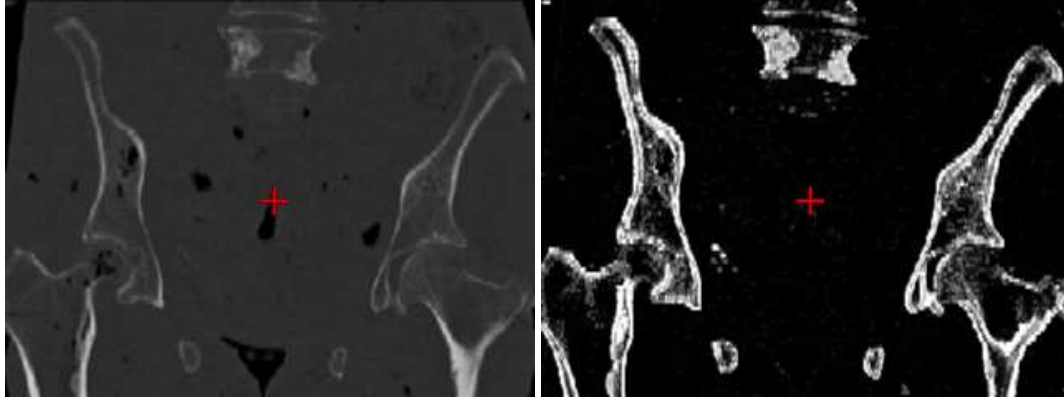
Pre-Processing of the CT image to a bone edge probability image. The image on the left is the CT image. On the right it has been converted to a bone edge probability image, using a Sobel filter, a local maximum filter, and a look up table.
